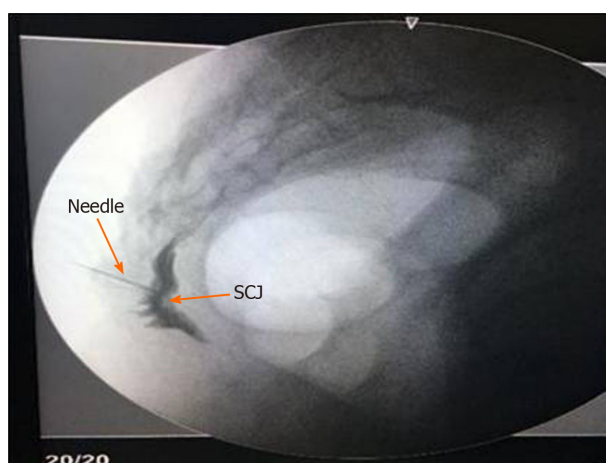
X-ray in the lateral position. Contrast scan showing the position of the puncture needle in the sacrococcygeal joint (SCJ).
